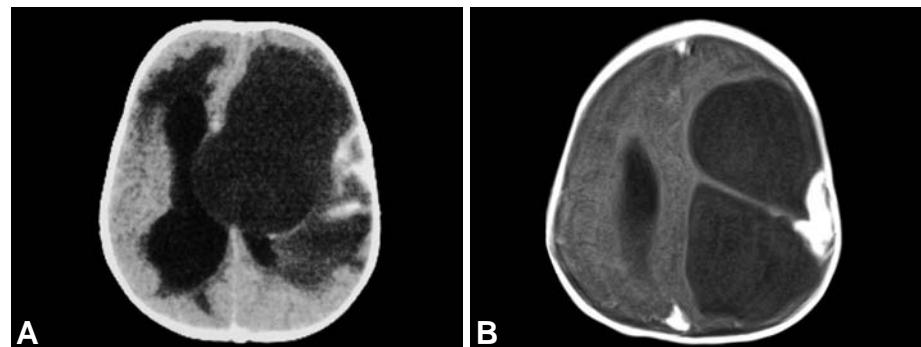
A CT scan of a desmoplastic infantile ganglioglioma with a solid component involving the superficial parietal lobe and large cystic component that extends across the midline. B Post contrast axial MR image demonstrating a superficial enhancing component of a desmoplastic infantile ganglioglioma together with a large septated cystic component that enlarges the skull and displaces the midline.
